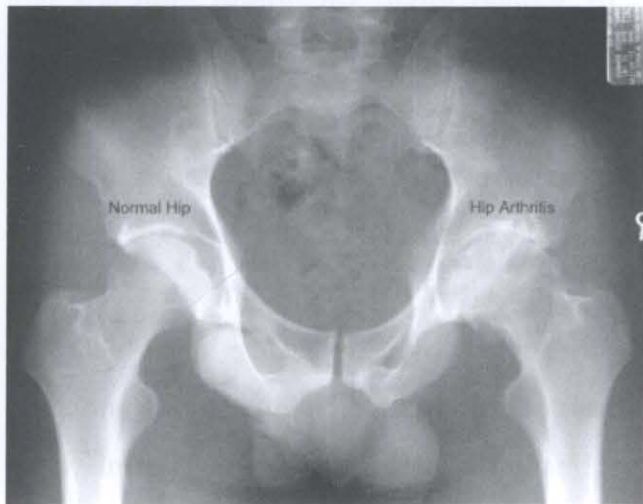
Diagnosis of hip OA: Loss of joint space visible on X-ray [47]
